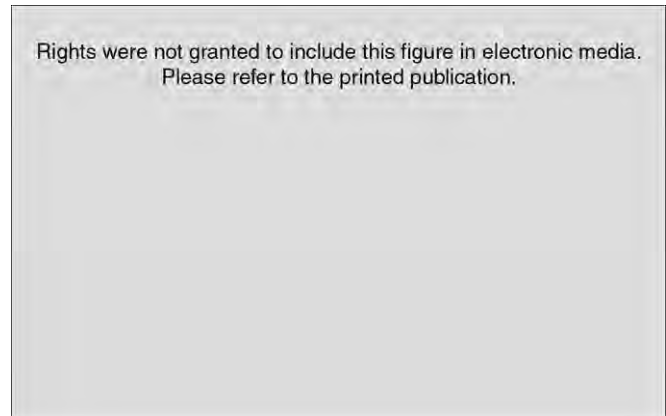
A pelvic CT view shows an inflamed sigmoid colon and adjacent tissues together with extraluminal gas confirming the diagnosis of diverticulitis. (From Markowitz SK, Kirejczyk W: Radiologic evaluation of the small and large intestines. In Welch JP, Cohen JL, Sardella WV, et al [eds]: Diverticular Disease: Management of the Difficult Surgical Case. Philadelphia, Lippincott Williams & Wilkins, 1998, p 103.)
